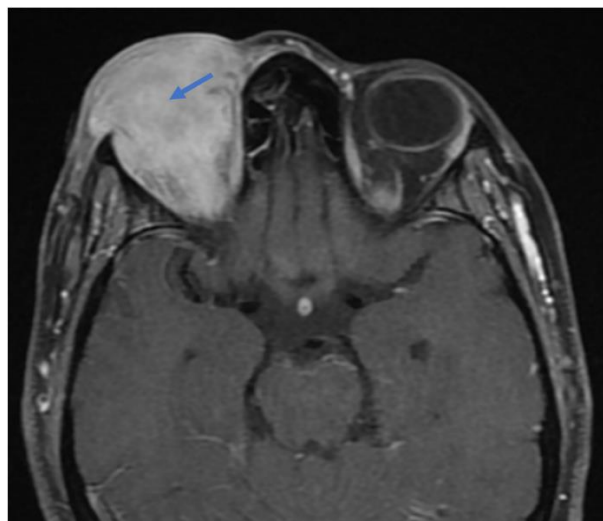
T1-weighted fat-suppressed MRI after contrast injection showing intense enhancement of the mass (blue arrow)
